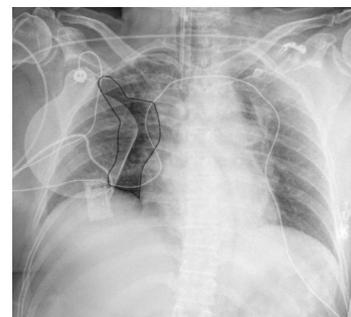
Anteroposterior chest X-ray, black delimitation showing the oligoemia part of the right lung.
